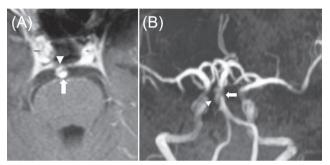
Magnetic resonance image (MRI) and magnetic resonance angiography (MRA) show dissection intimal flap with both true lumen (arrow) and false lumen (arrowhead) (A). A focal out-pouch pseudoaneurysm (arrowhead) and distal stenosis (arrow) (B).
